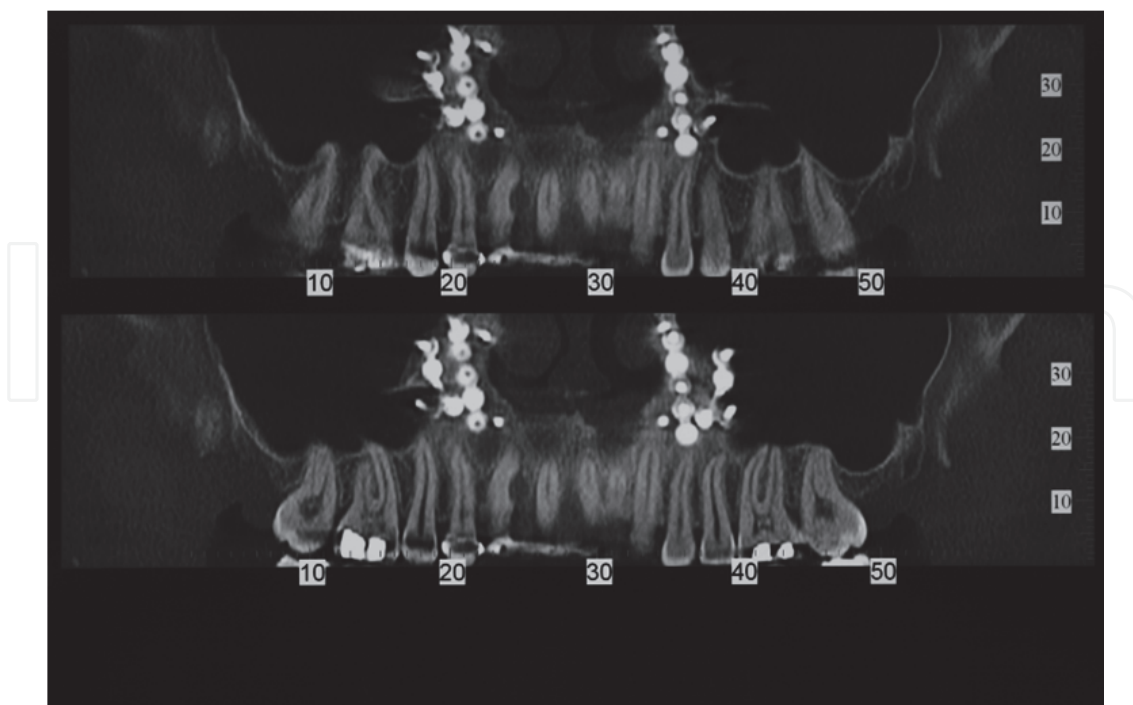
Panoramic CBCT view of the maxilla after a Le Fort I osteotomy
